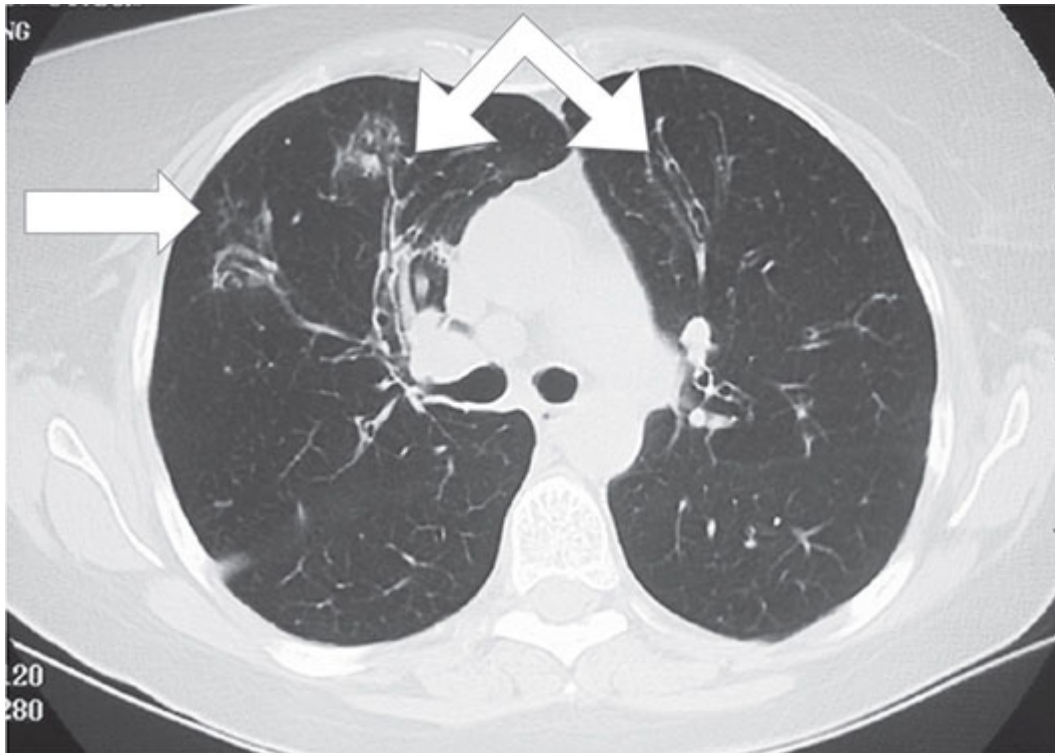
Chest CT of a patient with pulmonary *Mycobacterium avium* complex infection. Arrows indicate the “tree-in-bud” pattern of bronchiolar inflammation (peripheral right lung) and bronchiectasis (central right and left lungs).
